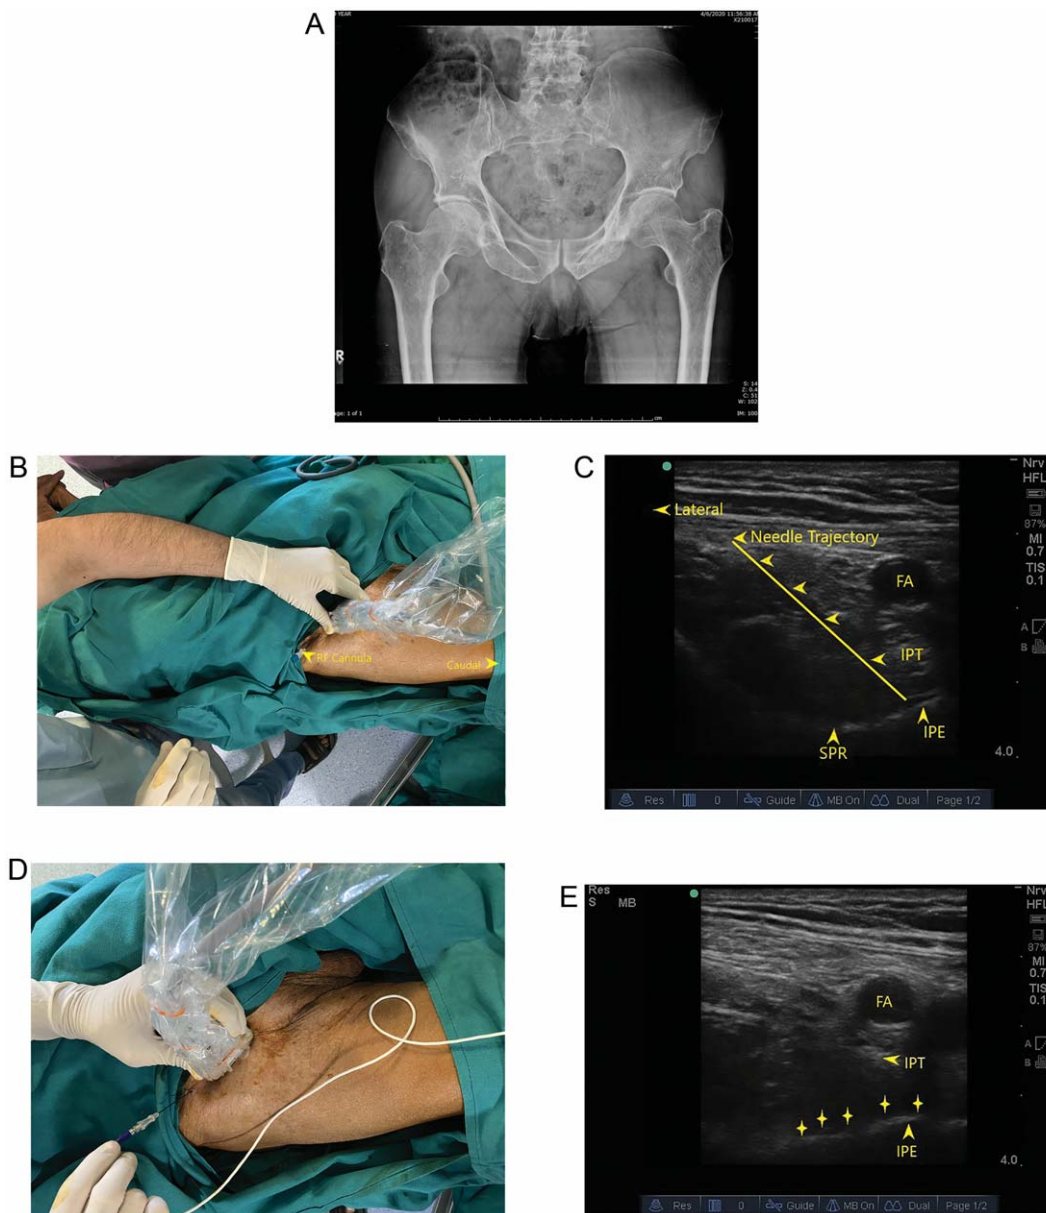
(A) X-ray of hip and spine showed bilateral hip joint osteoarthritis, age-related degenerative changes in spine, and sacroiliac joints. (B) 21G radiofrequency cannula was inserted in-plane using high-frequency linear ultrasound probe. (C) Cannula inserted until it contacted the superior ramus near iliopectineal eminence. (D) Radiofrequency probe inserted in cannula and PRF done after sensory stimulation. (E) Linear spread of local anaesthetic under the fascia of iliopsoas muscle. FA, femoral artery; IPE, iliopubic eminence; IPT, iliopsoas tendon; SPR, superior pubic ramus; – local anaesthetic spread.
